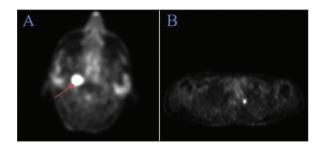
A) Positron emission tomography/computed tomography showing recurrent tumor, metastatic lymph nodes; B) Lung nodule images.
